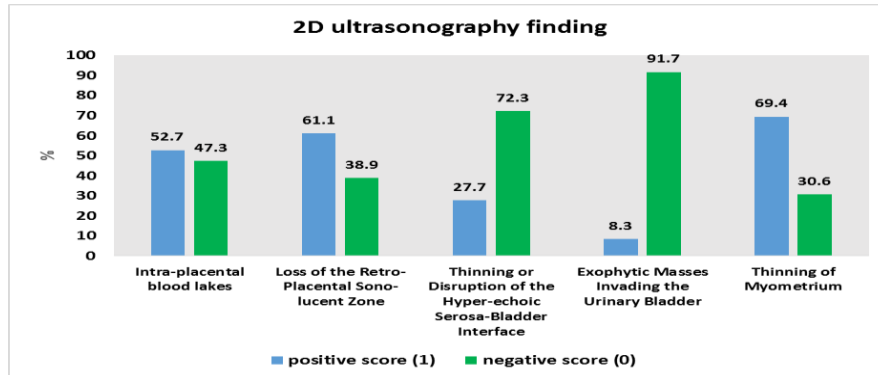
2D Ultrasonography Evaluation of the cases (PAS)
